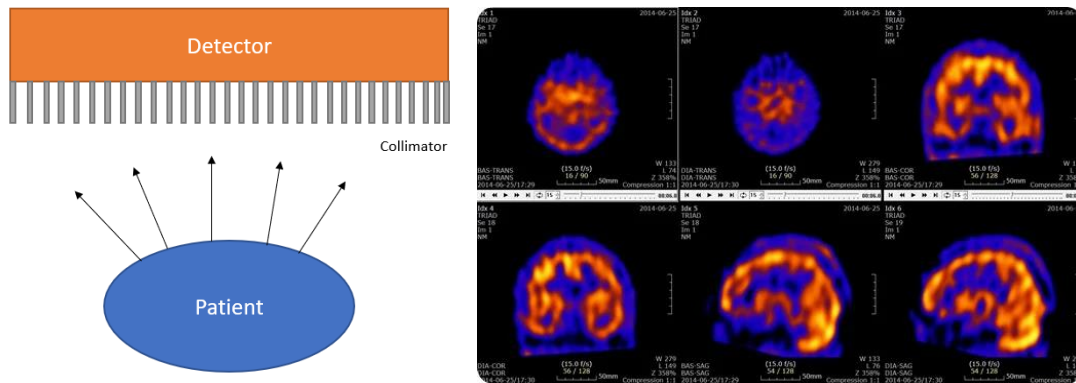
Left: Sketch of a gamma camera. Right: 3D views of a brain study using SPECT (www.news-medical.net).
